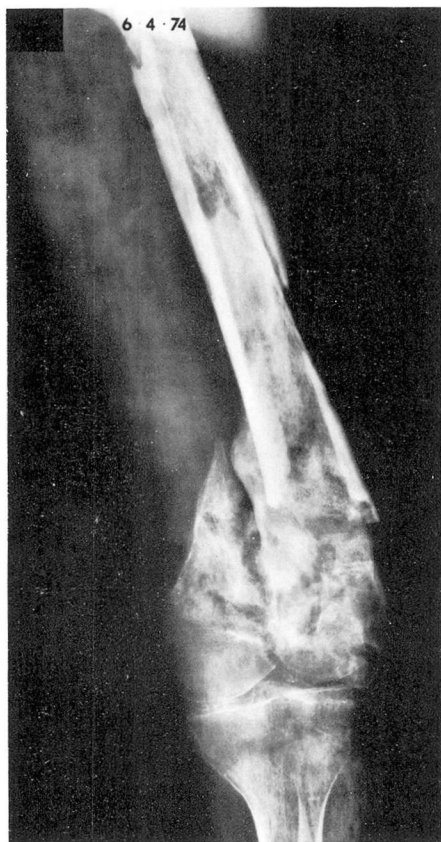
Roentgenogram of the femur on June 4, 1974, showing further evidence of osteomyelitis.
